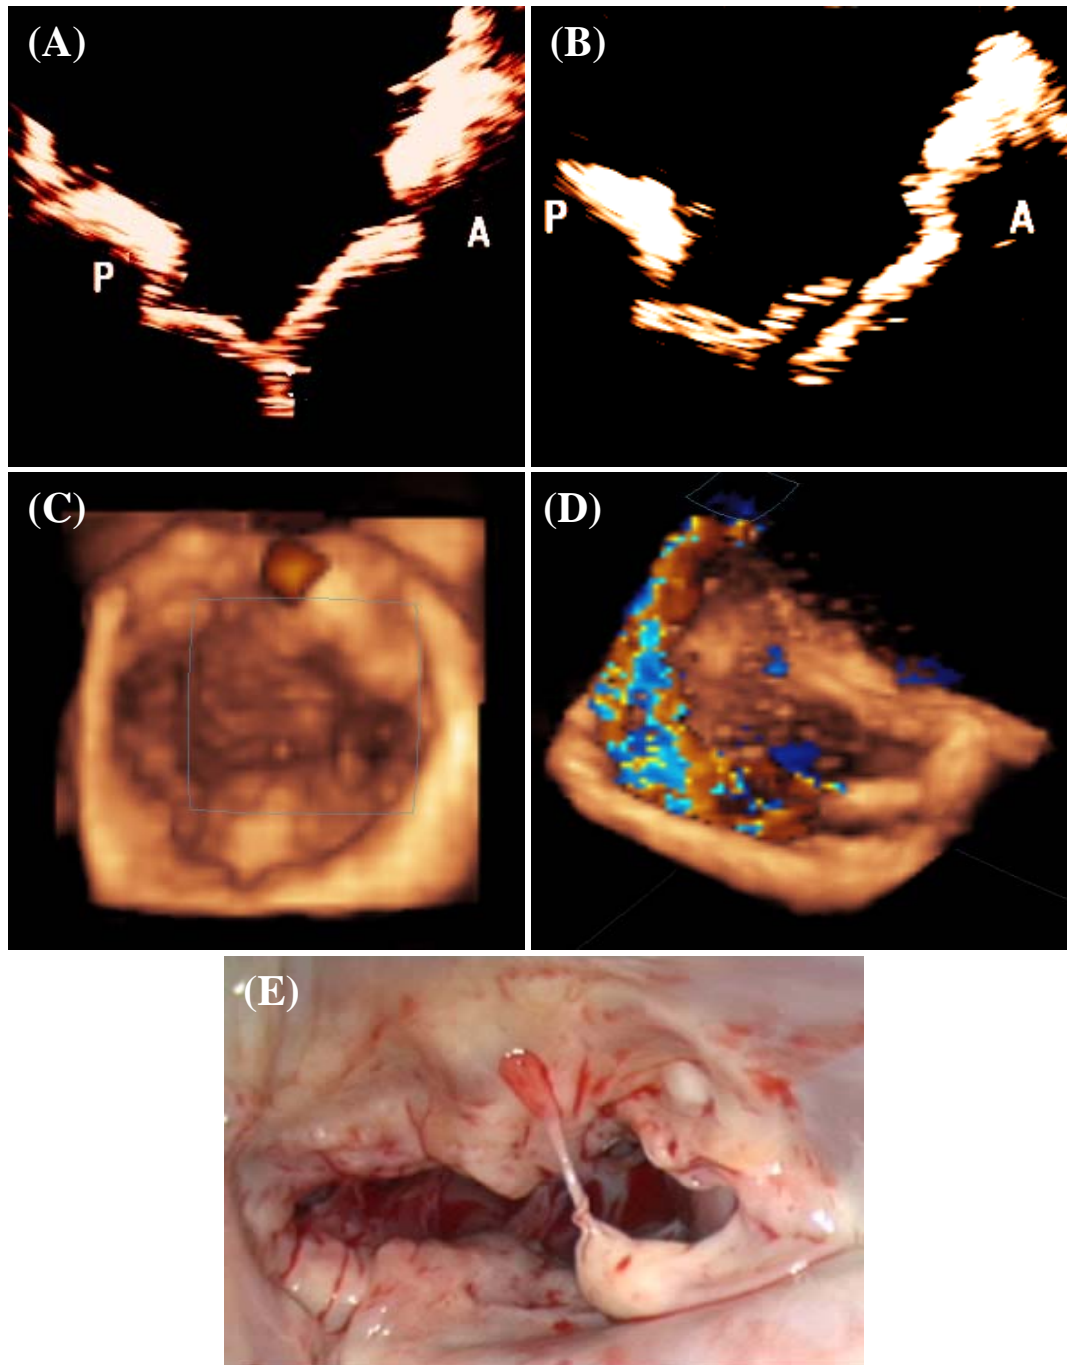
(A) 2D echo of a normal mitral valve with excellent coaptation, (B) Posterior leaflet prolapse after marginal chordal rupture, (c) 3D echocardiographic image of the normal valve with good coaptation, (d) An eccentric anteriorly directed regurgitation jet due to posterior leaflet prolapse, (e) An intra-operative image with an isolated ruptured chord on the posterior leaflet
